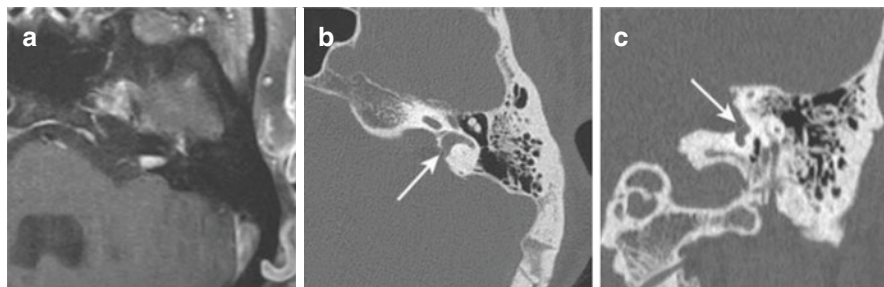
T1-weighted gadolinium-enhanced magnetic resonance image demonstrating a left intracanalicular vestibular schwannoma in axial view, which was subsequently removed via the retrosigmoid approach (a). Computed tomographic scan of the left temporal bone demonstrating postoperative dehiscence of the vestibule in axial view (b) and superior limb of the posterior semicircular canal in coronal view (c), with arrows pointing to site of dehiscence. (Adapted with permission from Bartholomew et al., 2019 [27])
